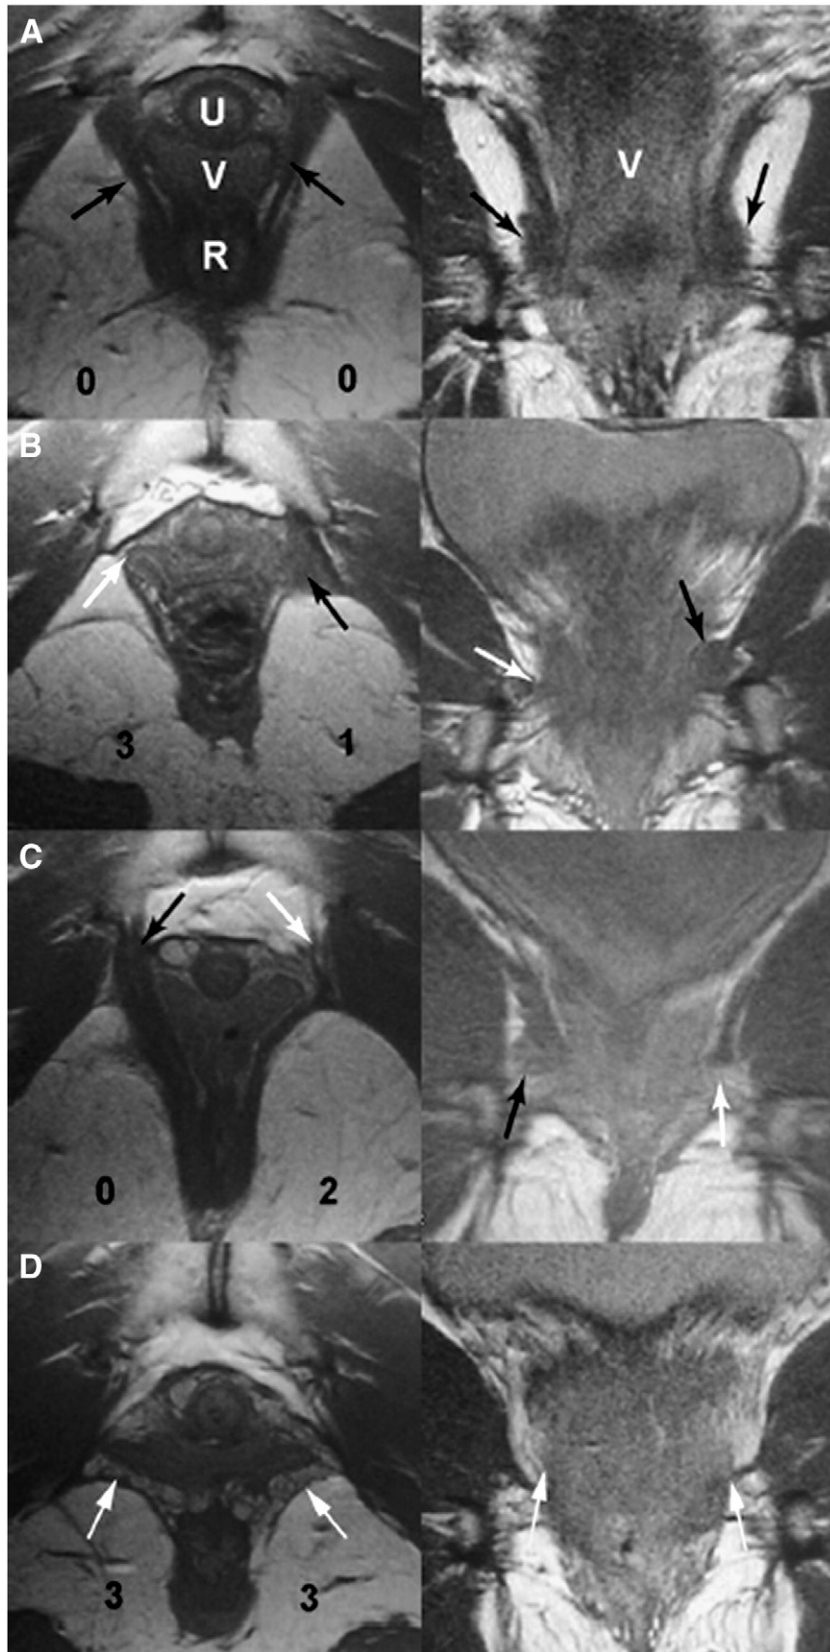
Examples of the appearance of different grades of levator ani pubovisceral muscle defects in axial and coronal magnetic resonance images. Example A represents a woman with normal muscles; B and D represent women with major defects, and C, a woman with a minor defect. Defect scores in the left panels represent the scores for each side. *Black arrows* identify normal muscle and *white arrows* represent areas where muscle is defective or should be present. U, urethra; V, vagina; R, rectum. Reproduced, with permission, from Ref. [4].
